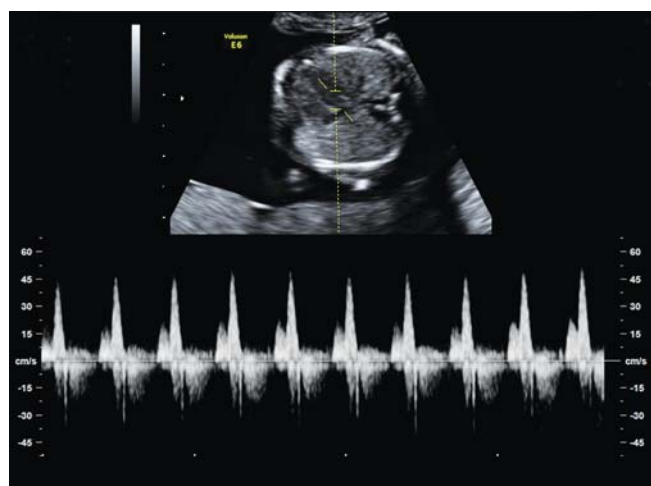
Early fetal echocardiography by 2D and power Doppler. Normal mitral wave flow by power Doppler
